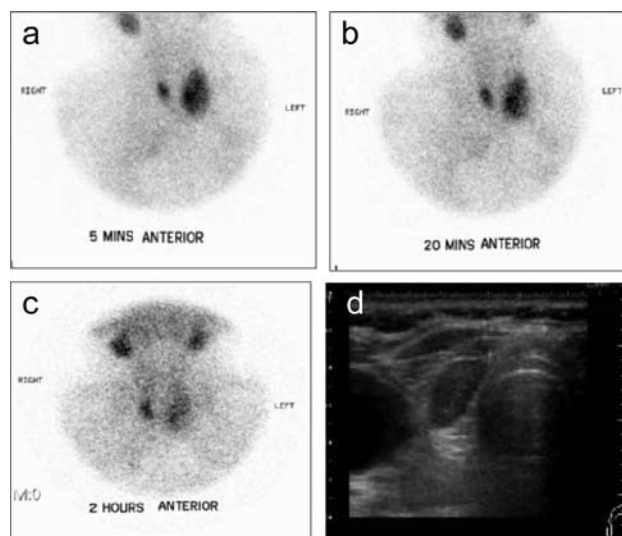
Pre-operative imaging in patient with previous right thyroid lobectomy. (a–c) ^{99m}Tc-sestamibi scan showing delayed washout on right side of neck. (d) Neck ultrasound scan showing 12 mm parathyroid adenoma in right side of neck.
